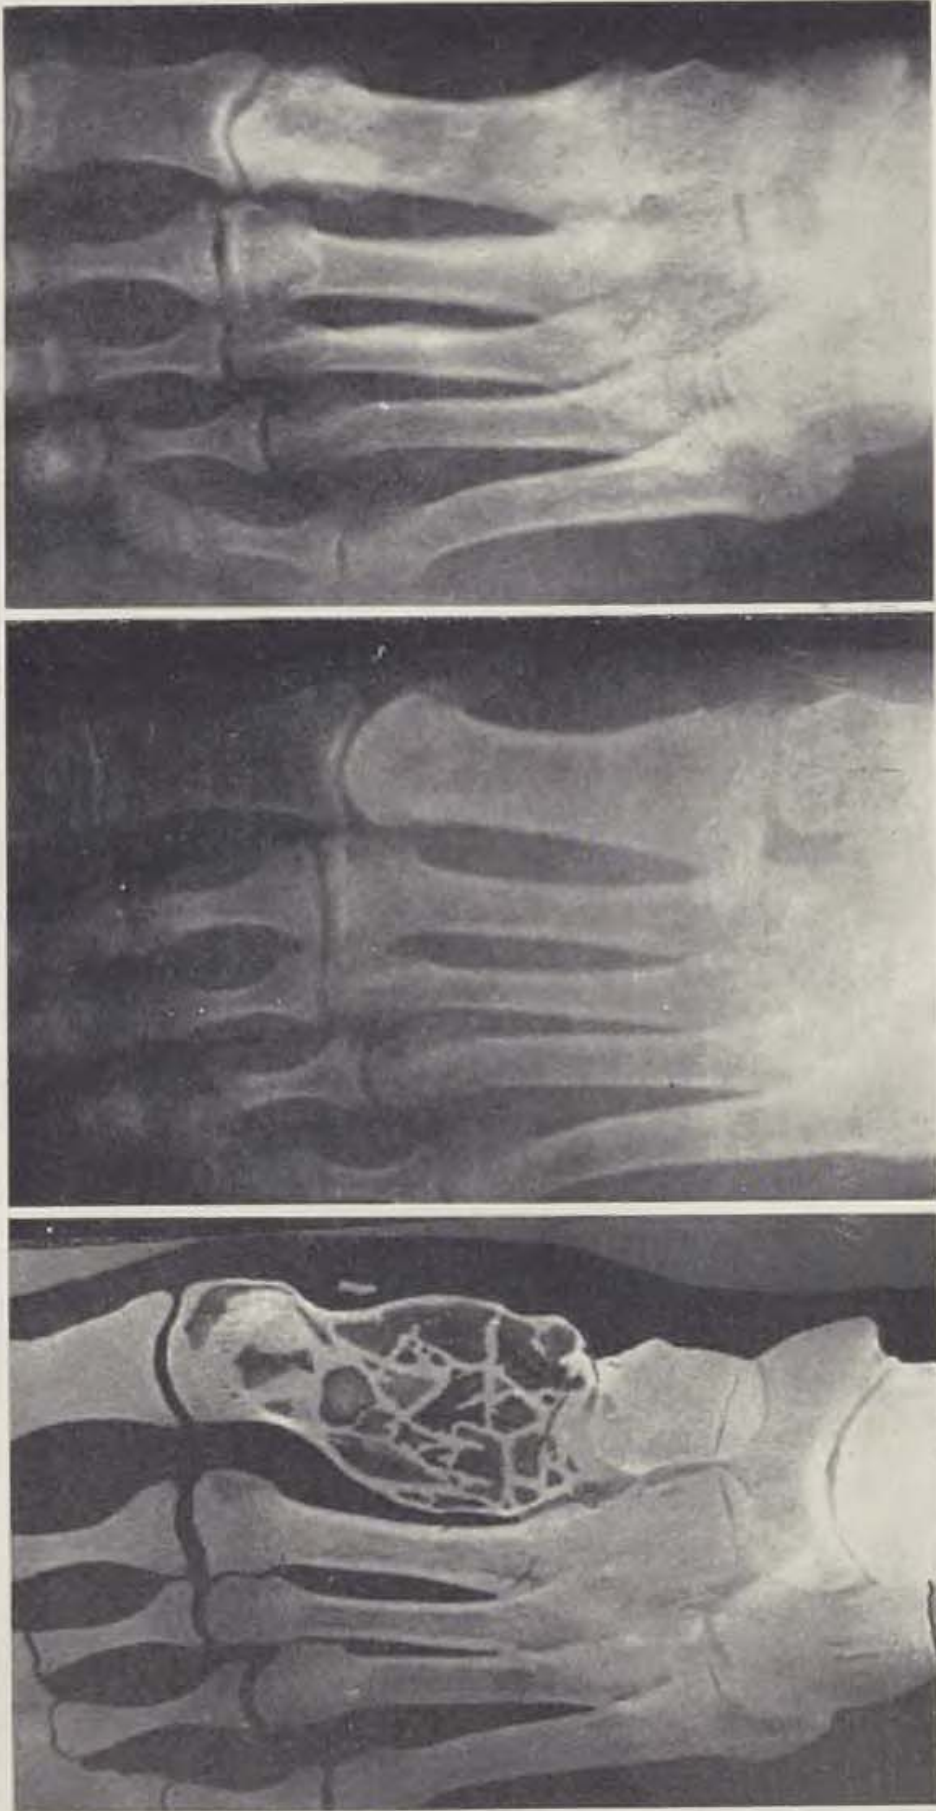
Patient V. The roentgenogram taken before extirpation of the first metatarsus. — Fig. 2. The same patient. Five years after the surgical reconstruction of the first metatarsal bone using an allograft in the case of osteoblastoclastoma. — Fig. 3. The same patient. Thirteen years after the operation.
